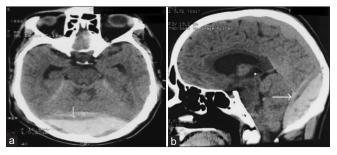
(a) Preoperative axial computed tomography (CT) scan head showing posterior fossa Epidural hematoma (EDH) with swirl sign (thin arrow) (b) preoperative sagittal CT scan head showing EDH in both supratentorial and infratentorial compartments (thin arrow).
